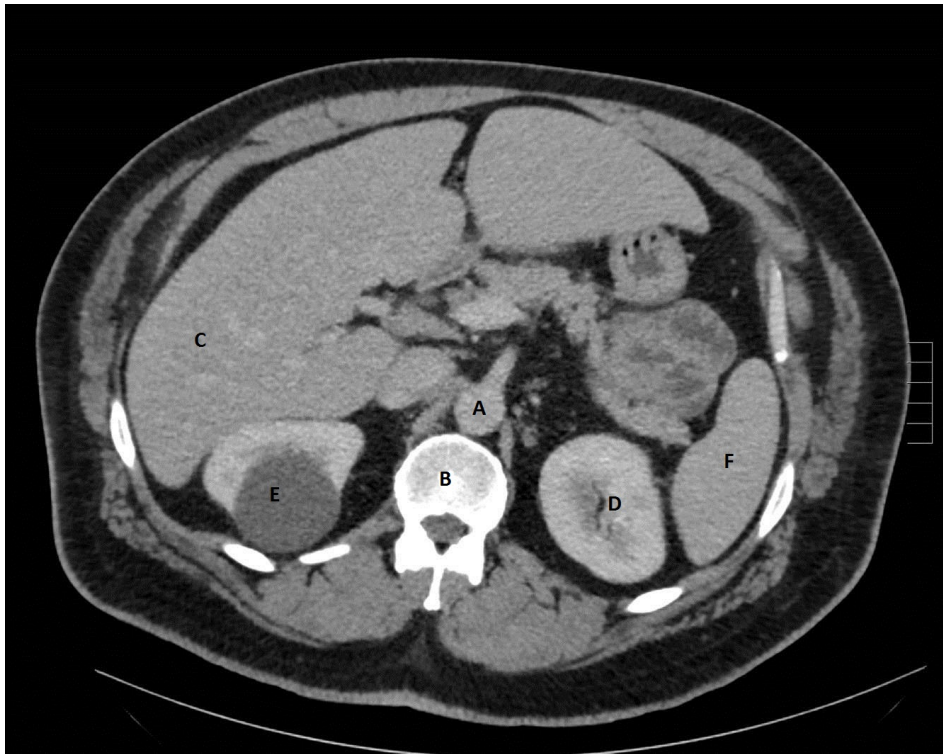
A typical medical CT image A: Aorta, B: Spine, C: Liver, D: Kidney, E: Cyst, F: Spleen. Image Courtesy of the Princess Alexandra Hospital, Radiology Department.
